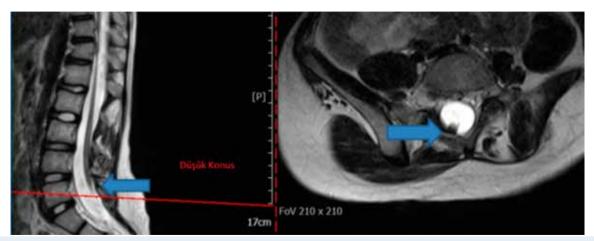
Low conus medullaris and thick tight filum terminale at L5 level can be seen at T2-weighted axial and sagittal MRI preoperatively in one of our cases.
